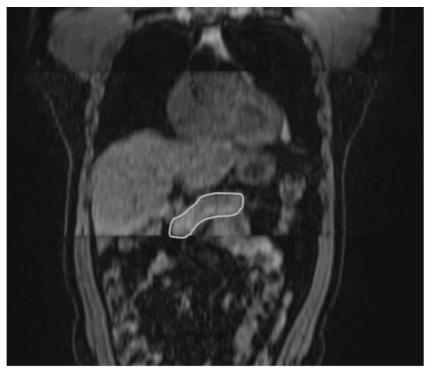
Anatomical location of the pancreas shown on a sagittal MRI image.
